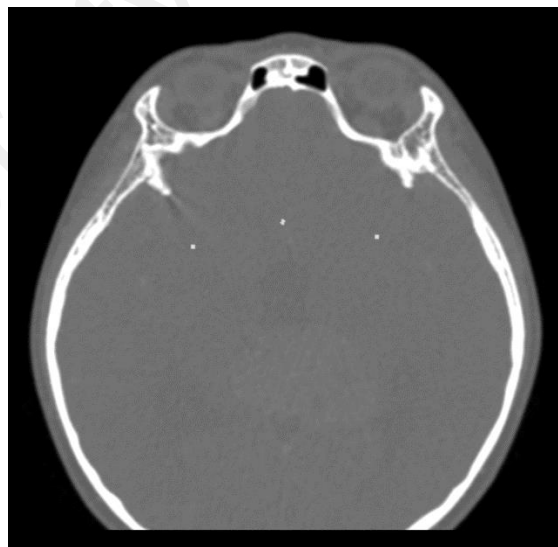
Three of 24 reference points incorporated inside the CT Image of the patient to be printed.
